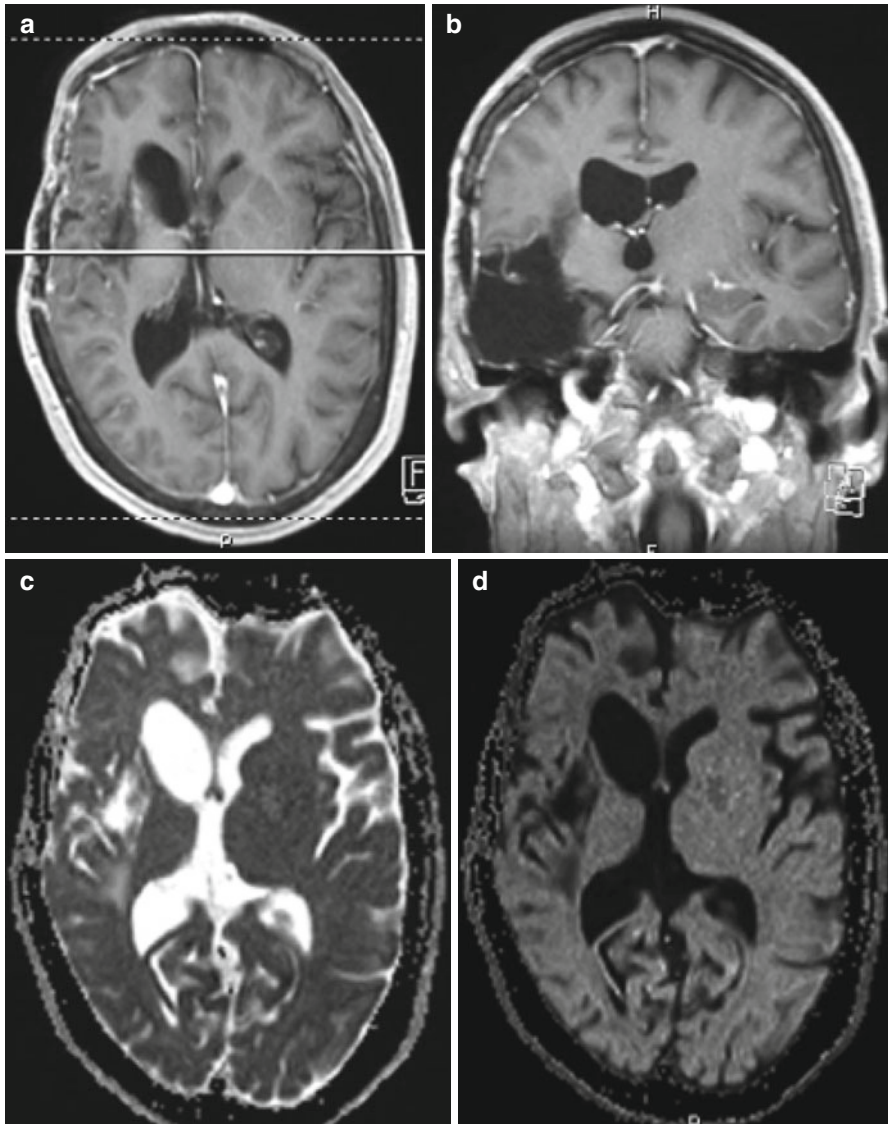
Photography of an MR scan after temporo insular surgery, showing an ischemic stroke in the region of the corona radiata above the internal capsule. (a) Axial T1 MRI scan with contrast injection, (b) coronal T1 MRI scan with contrast injection, (c) axial ADC (apparent diffusion coefficient) MRI scan, and (d) axial diffusion MRI scan
